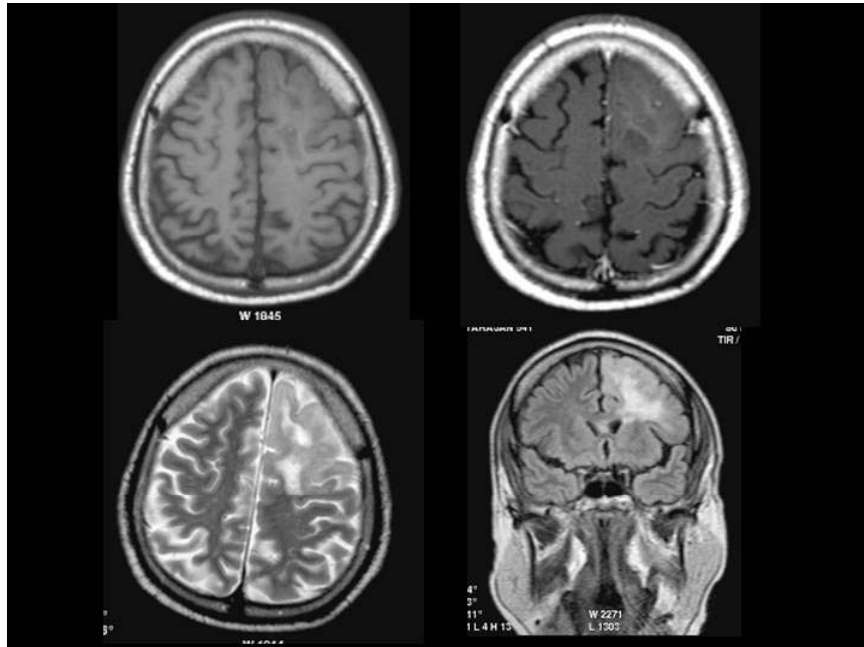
MRI shows thickening of gyri with signal alteration on T2 WI in the left medial frontal cortex and no enhancement on contrast study- low grade neoplasm
